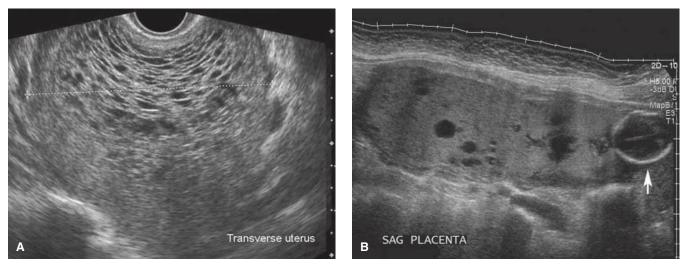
Sonograms of hydatidiform moles. A. Transverse view of a uterus with a complete hydatidiform mole. The characteristic "snowstorm" appearance reflects an echogenic uterine mass, marked by calipers, that has numerous anechoic cystic spaces. Notably, a fetus or amnionic sac is absent. B. In this sagittal image of a partial hydatidiform mole, the fetal head (*arrow*) lies adjacent to an enlarged, multicystic placenta.
